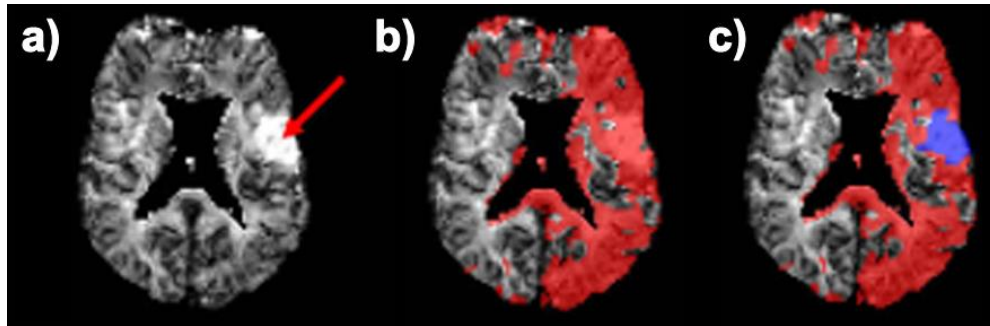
Imaging the ischaemic penumbra in acute stroke with MRI (image adapted from [19]). (a) DWI hyperintensity (red arrow) corresponds to the infarct core. (b) PWI shows regions of reduced blood flow (red region). (c) Subtracting the DWI infarct region (blue) from the PWI produces a diffusion-perfusion mismatch image, showing ischaemic penumbra. The red region now corresponds to potentially salvageable tissue.
